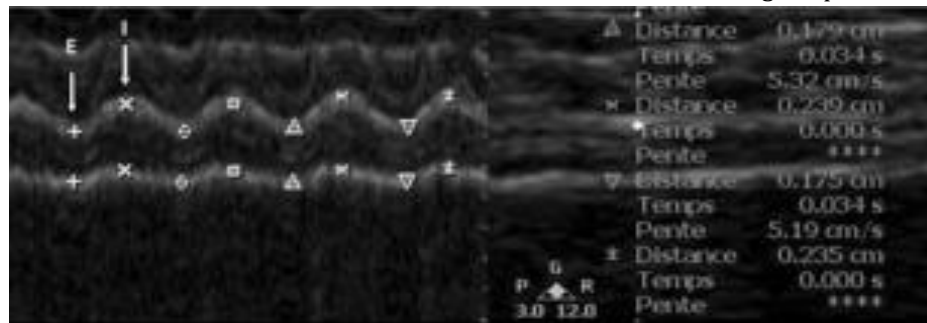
Sonography of the diaphragm in the zone of apposition, in B-mode (right) and M-mode (left) during quiet breathing. E and I arrows indicates expiration and inspiration, respectively.
